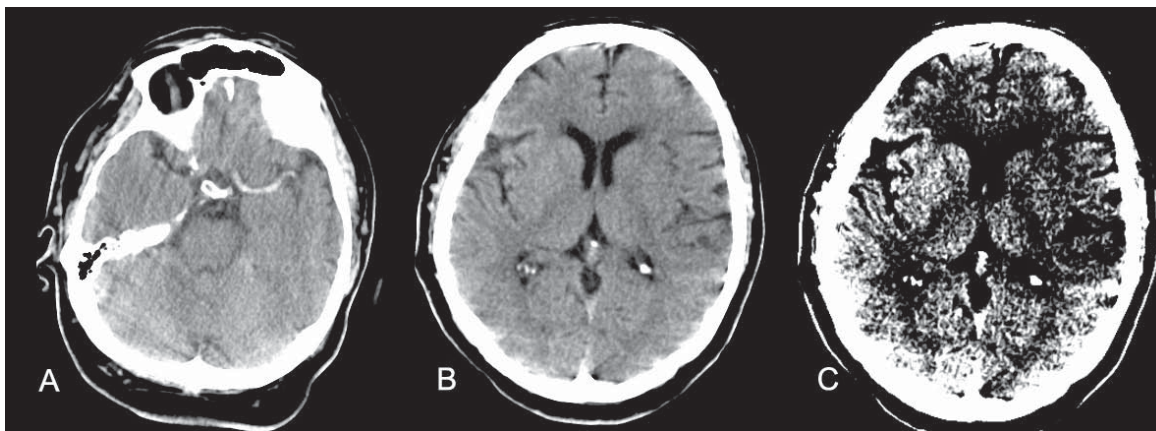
CT signs of acute stroke. Hyperdense middle cerebral artery (A) on the left side; Obscuration of left lentiform nucleus (B) is more pronounced on "narrow window" CT (C)
